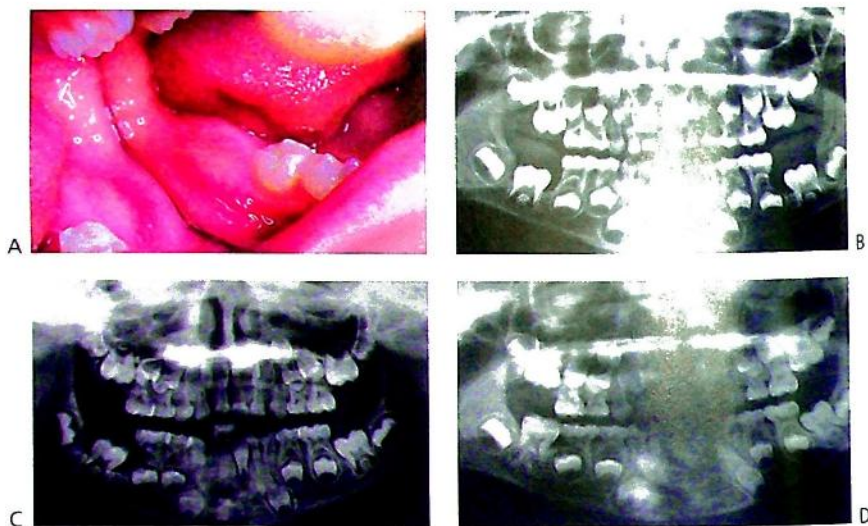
An unusual case of bilateral dentigerous cysts associated with the both lower first permanent molars. (A) Uninflamed swelling distal to the second primary molar. (B) Radiographic changes showing expansion of the follicle and resorption of the root of the lower left second primary molar. (C) A large dentigerous cyst around the crown of the tooth 46. This was managed by marsupialization. (D) The appearance 6 months post surgery showing bony infill and eruption of the tooth.
